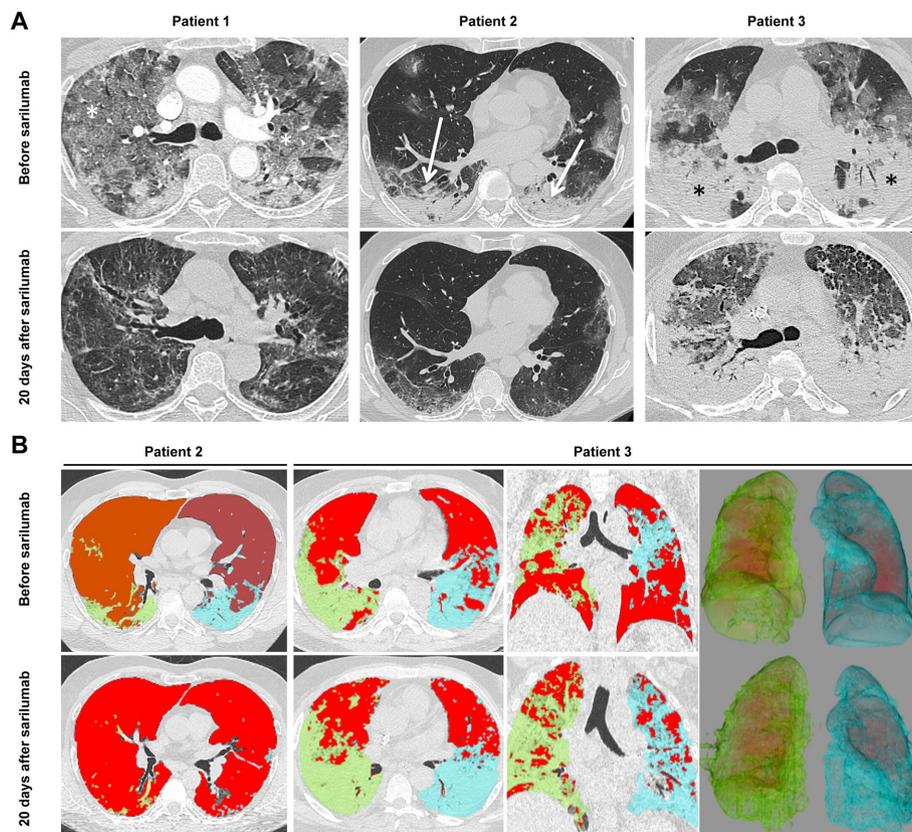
Imaging findings before and after sarilumab. (A) CT scan showing radiological improvement of bilateral ‘ground-glass’ opacities (asterisk) and lung consolidations (arrows) 20 days after enrolment in a patient treated with standard of care (patient 1) and in one treated with sarilumab (patient 2) having a volume of lung consolidation <17% at baseline. CT scan showing worsening of lung consolidations (asterisks) 20 days after sarilumab in a patient with a volume of lung consolidation >17% before infusion (patient 3). (B) Semiautomatic segmentation and quantification analysis of CT scans of patient 2 (axial) and patient 3 (axial, coronal and volume rendering) before and after sarilumab. Lung consolidations are shown in green (right lung) and blue (left lung).
